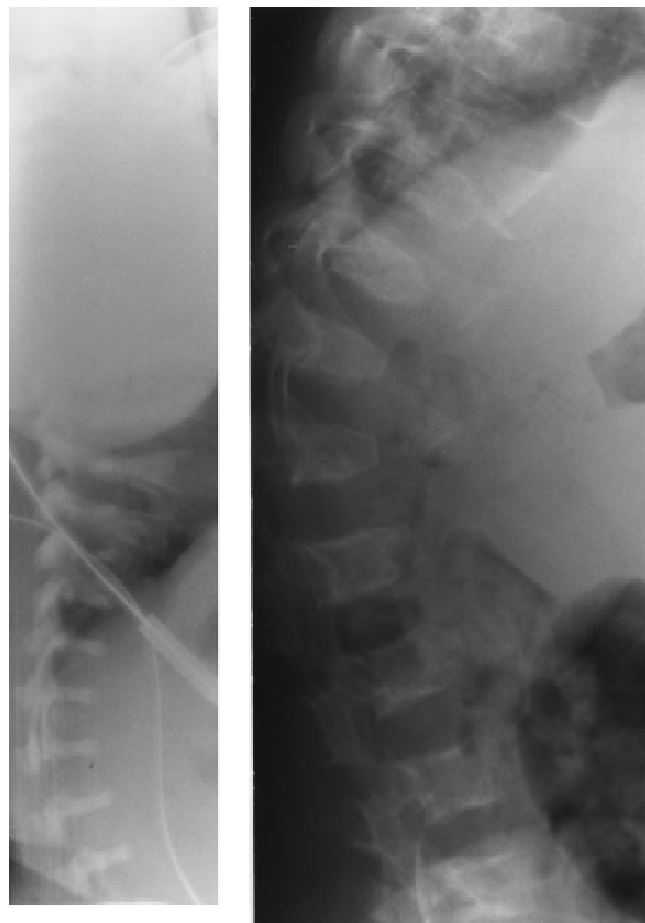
Lateral spine radiographs, at birth (left) and 7.2 years (right).
